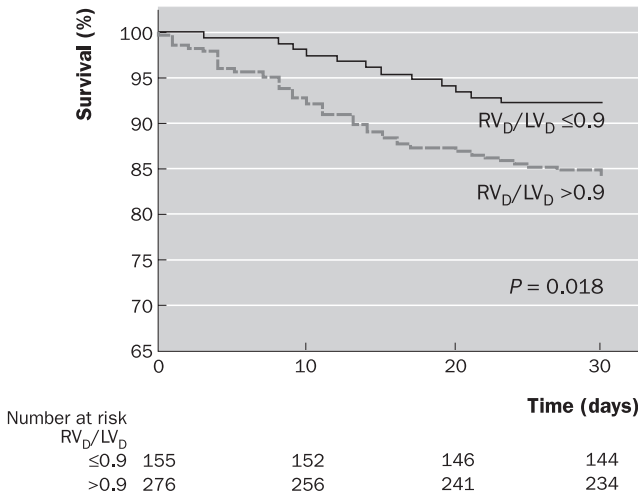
Survival in 431 patients with acute PE according to the presence or absence of right ventricular enlargement on reconstructed CT 4-CH view. Probability values are from the log-rank test. Source: Schoepf *et al.* (2004).
